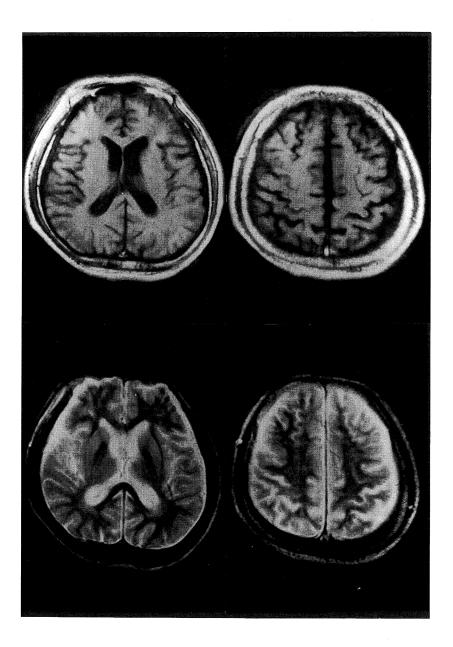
MR imaging of the brain was carried out after 30 days at hospital. The MR imagings show enlarged lateral ventricles and cisterns, and diffuse atrophy of the brain. T2-weighted images (lower row) show hyperintensity of the cerebral cortex. The basal ganglia and thalamus were slightly hyperintense.
